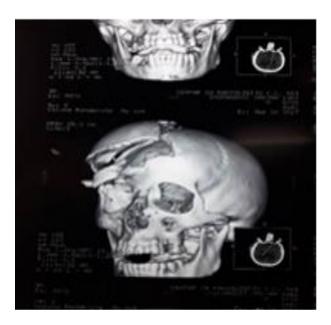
Expressed fracture - CT of the brain with bone window showed bone fragments out of which larger part of the right half of frontal squama descending to orbital roof was significantly above in relation to other depressed bone fragments
